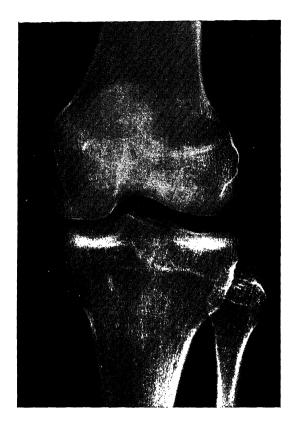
Radiograph of an adult knee. The gap between the lateral condyles of the femur and tibia is occupied by the articular cartilage of the two bones and the lateral semilunar cartilage.
